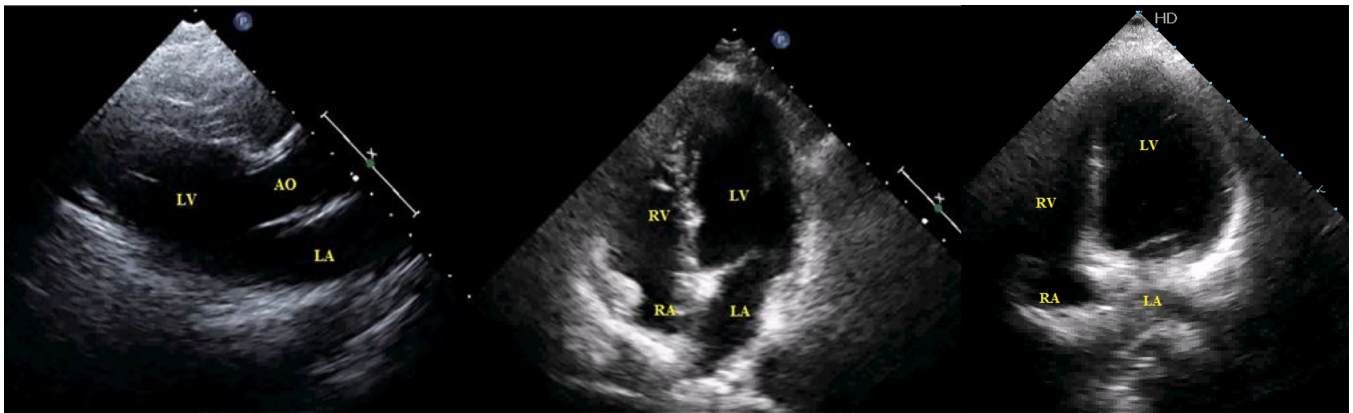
2D echocardiography parasternal long-axis view showed normal LV and apical four-chamber view showed normal LV. LV, left ventricle.
